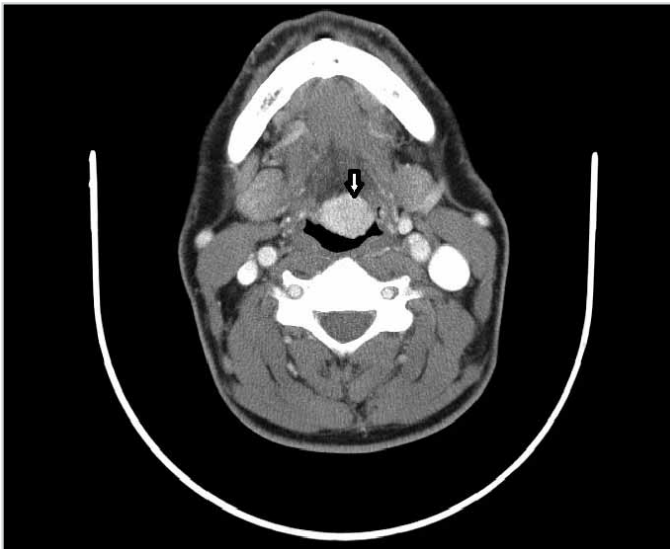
Ectopic lingual thyroid under contrast-enhanced computed tomography (white arrow)
